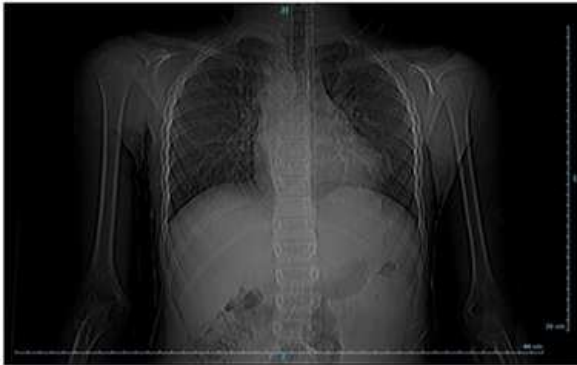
The patient's chest X-ray
